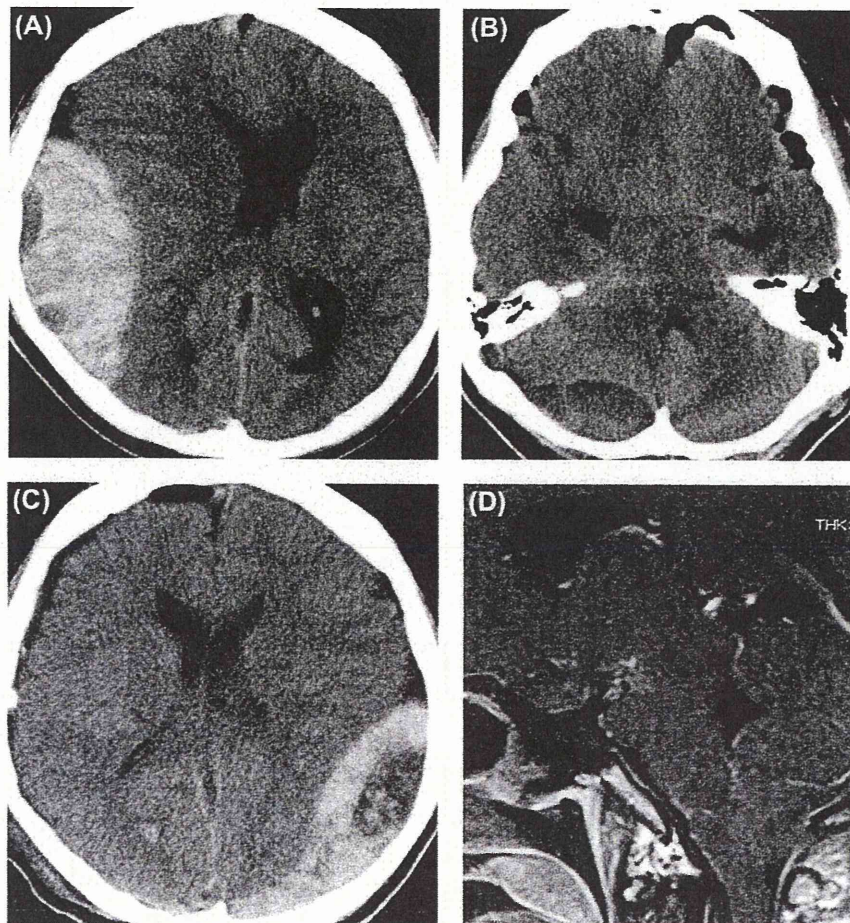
Initial post-operative CT scan shows an extradural haematoma in the right parieto-occipital (A) and right posterior fossa region (B). CT at the time of the second episode (C) shows left parietal extradural haematoma. Sagittal T1-weighted magnetic resonance imaging (D) shows caudal brain displacement with downward herniation of the third ventricle to the dorsum sellae.
